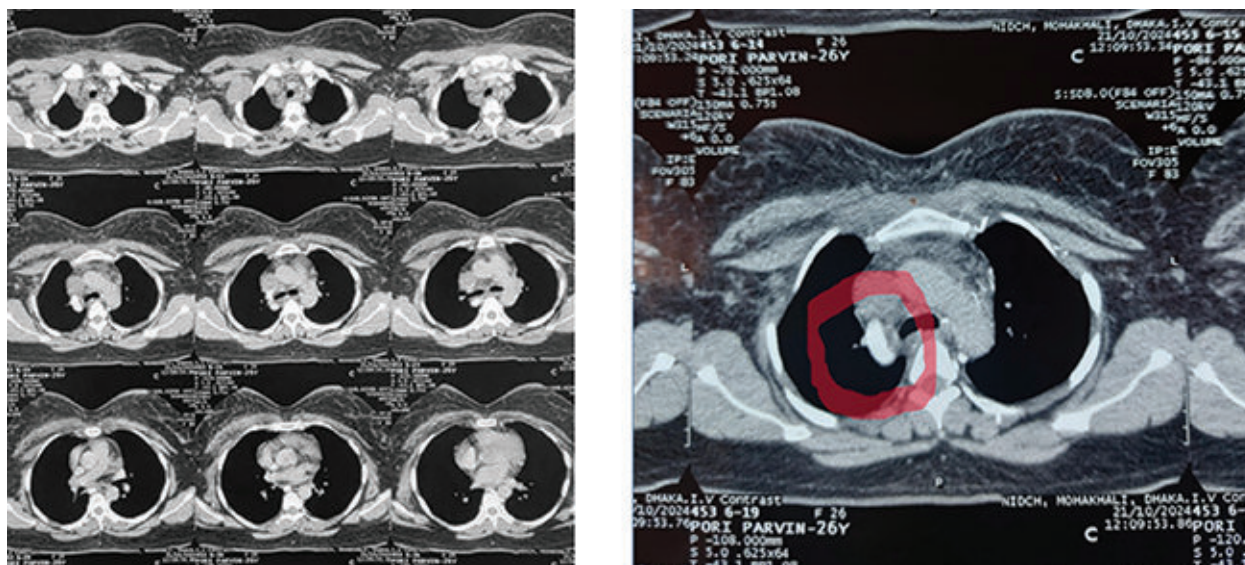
(A&B): CT scan of Chest showing soft tissue density filling defect within the SVC lumen. This thrombus extended superiorly into the right internal jugular vein via the right brachiocephalic vein and into the terminal left brachiocephalic vein. A soft tissue lesion in the right infraclavicular region suggested lymphadenopathy, but no significant mediastinal lymphadenopathy was found.
